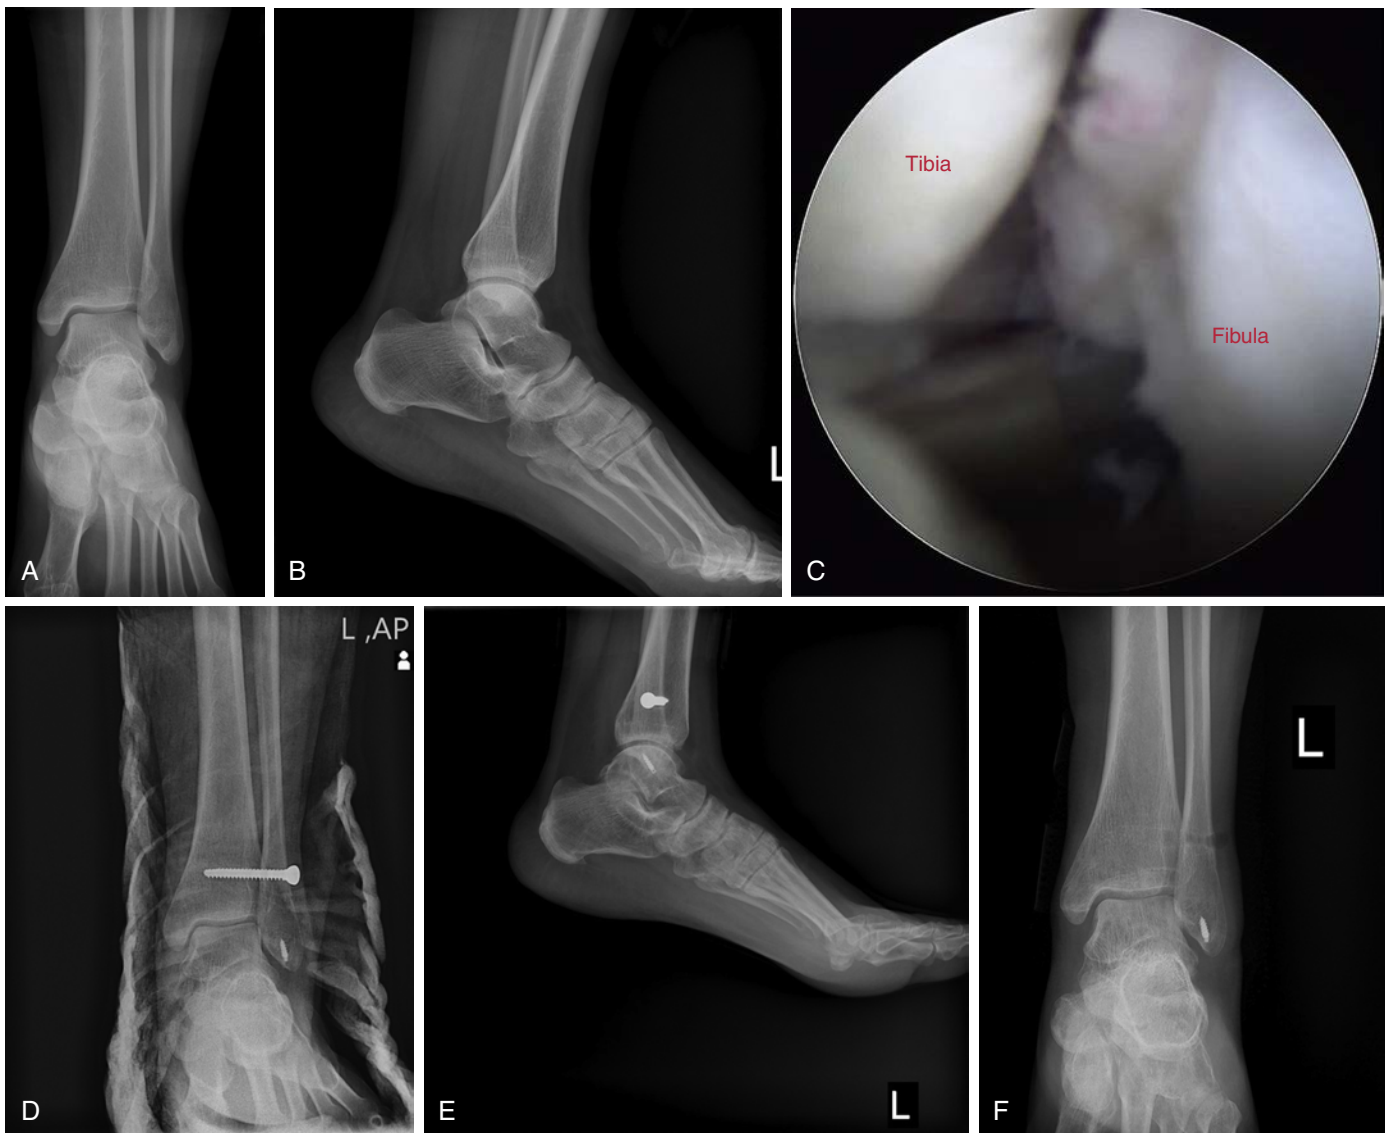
High ankle sprain in an athlete from repetitive twisting activity. A and B, preoperative radiograph shows no problem. C, Arthroscopy was performed because of persistent pain on anterior inferior tibiofibular ligament (AITFL) and syndesmosis. There was a positive arthroscopic cotton test with marked synovitis. The 3-mm shaver is easily passed into syndesmosis space, indicative of instability. D and E, early postoperative. F, Four months after operation the syndesmotic screw was removed.
